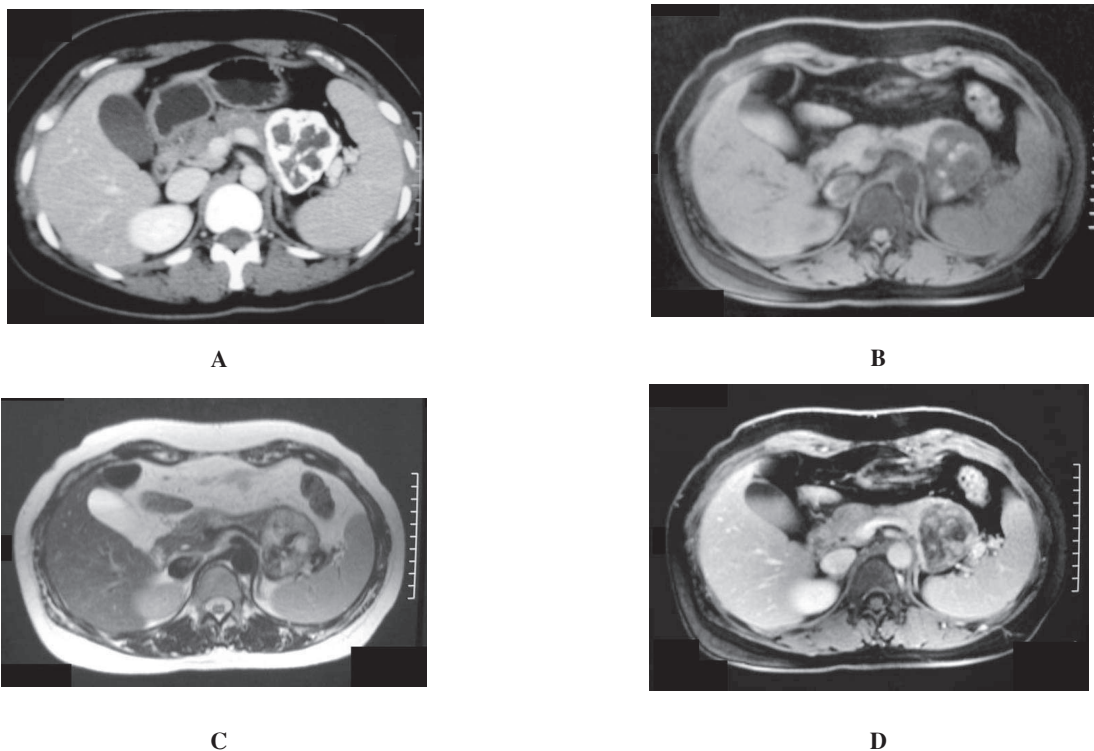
Abdominal CT examination showed a large whirl-like calcified tumor of the pancreas tail. The non-calcified solid portion of the tumor showed moderate enhancement (A). T1-weighted MR imaging showed a round, well-circumscribed, hypointense mass in the pancreas tail (B). The mass was slightly hyperintense on T2-weighted imaging (C), and contained cystic and hemorrhagic components which were hyperintense on T1- and T2-weighted imaging. Gd-enhanced T1-weighted imaging showed moderate enhancement in the solid component (D).
